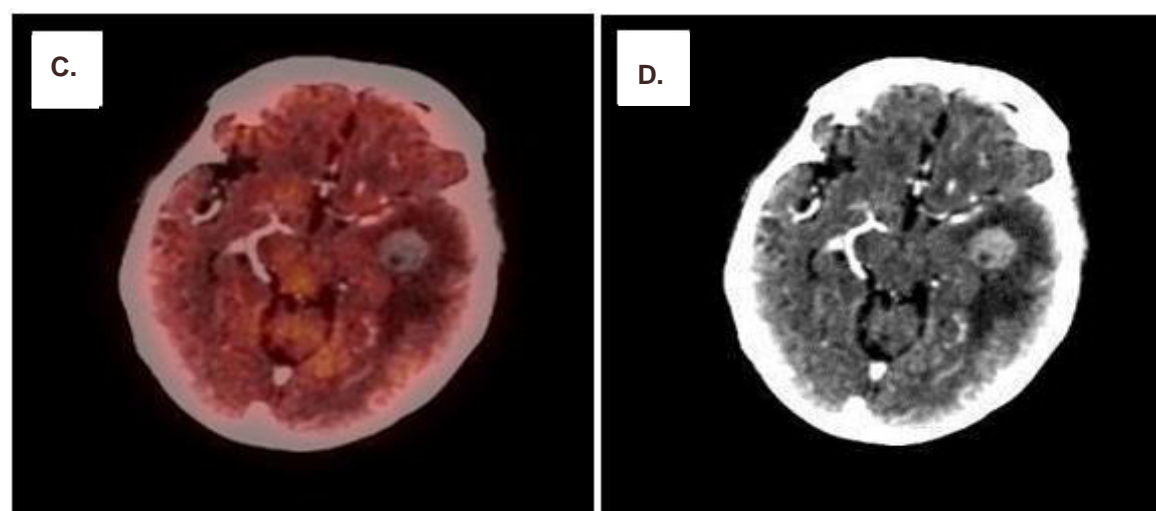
(C, D) Shows uniformly enhancing rounded soft tissue in the left temporal lobe, likely representing a nodular granular stage of neurocysticercosis which shows no significant FDG uptake on the fused PET/CT images.
